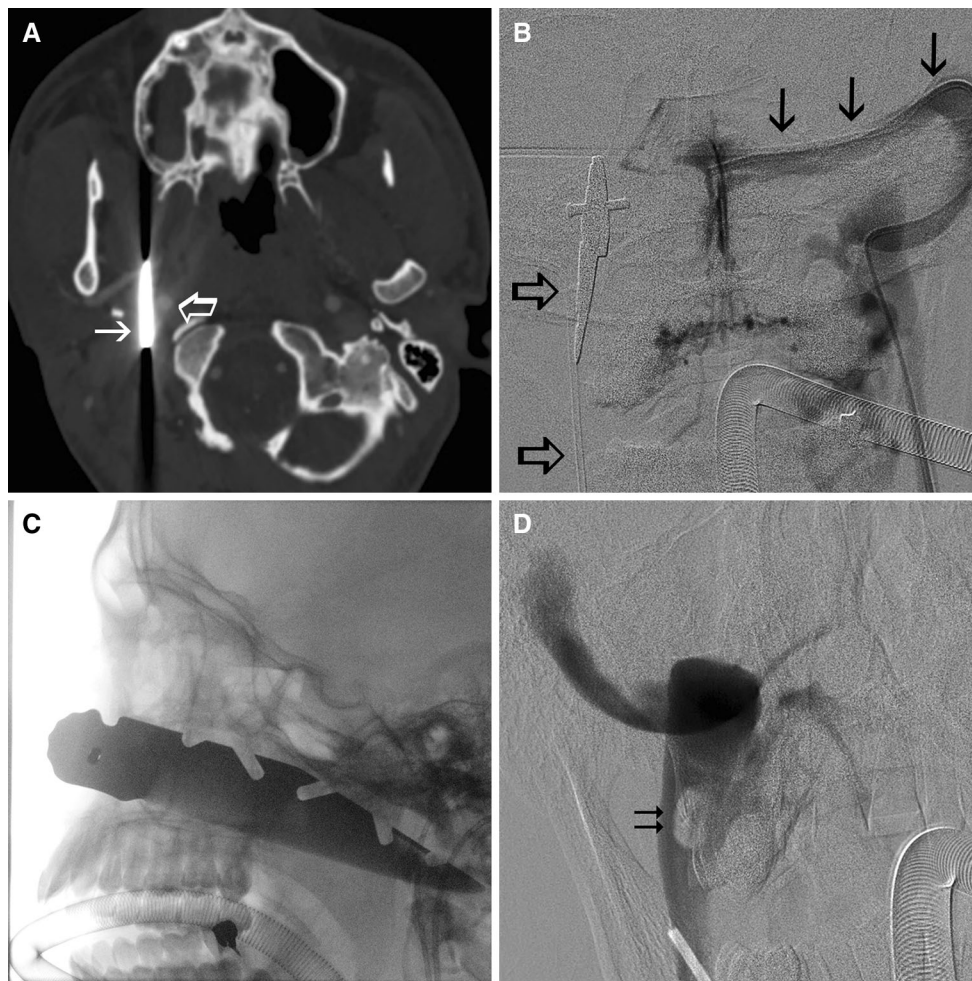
20 year-old male patient presented with penetrating stab wound injury to the anatomic Zone III of the right neck, with a 12 cm serrated knife blade retained in the skull. a Axial contrast-enhanced CT image showing the blade apparently traversing the right internal jugular vein (arrow), and retained in a very close proximity to the right internal carotid artery (open arrow) with no significant surrounding hematoma. Removal of the blade under fluoroscopy guidance and angiographic control was planned. Carotid and vertebral angiography and internal jugular venography was performed to rule out active extravasation or arterial dissection. Balloon catheters were introduced in the right internal carotid artery to occlude the artery should any bleeding occur while retrieving the blade. b The contralateral left internal jugular vein was catheterized (arrows) to
